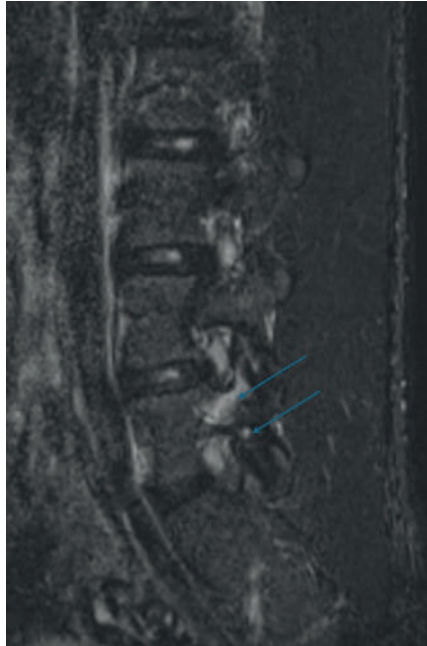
STIR MRI showing bone marrow edema associated with pars stress reaction. Sagittal short tau inversion recovery (STIR) magnetic resonance image of the lumbar spine demonstrating hyperintense signal within the pars interarticularis and adjacent pedicle at the L5 level (arrows), consistent with bone marrow edema related to an early stress reaction in spondylolysis. STIR sequences are highly sensitive for detecting active inflammatory changes and bone marrow edema before the development of a complete cortical defect.
